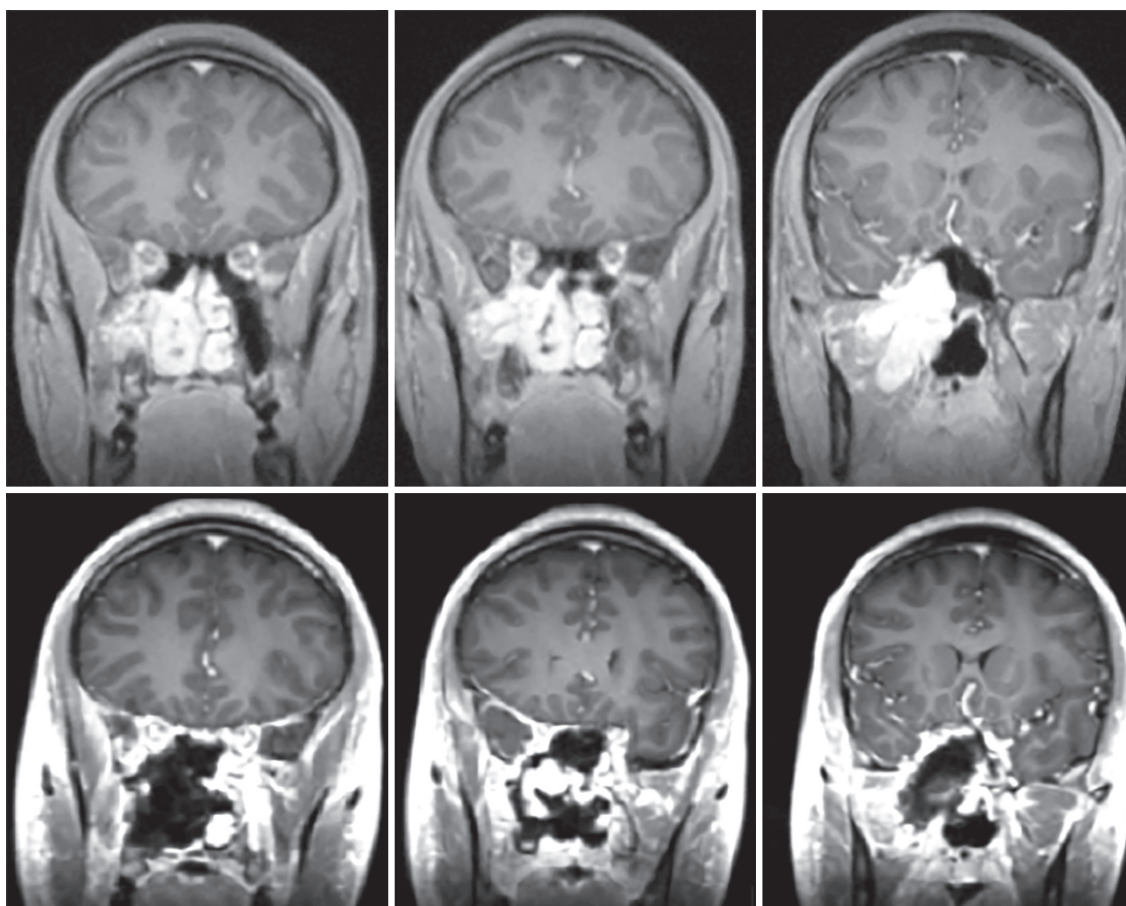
Preoperative and postoperative magnetic resonance imaging from an extensive, recurrent right-sided juvenile nasopharyngeal angiofibroma.
